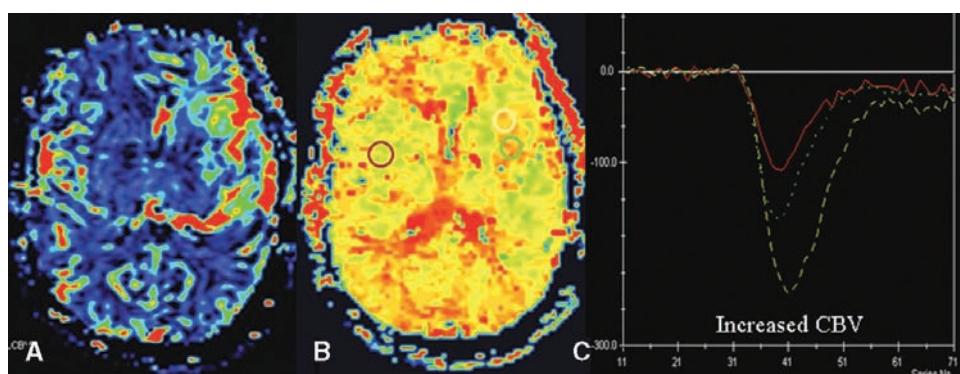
(A) Gradient-echo axial DSC MRI with rCBV color overlay map, and (B) MTT color overlay map demonstrates a high CBV in the lesion and the perilesional regions. (C) Signal intensity versus time curves color coded to the three ROIs placed on the MTT map demonstrates high CBV (area under the signal intensity curves) in the yellow ROI and to a lesser extent in the green ROI, which have been placed at the lesion, compared with the red ROI of the contralateral normal parenchyma. Increased CBV in the lesion and the perilesional regions was highly suggestive of a high-grade glioma with tumor infiltration into the surrounding tissues. In tumoral disease MTT/TTP may be increased or decreased and is less specific. The final diagnosis was anaplastic astrocytoma. Abbreviations: DSC MRI, dynamic susceptibility contrast MRI; rCBV, relative cerebral blood volume; MTT, mean transit time; ROI, region of interest; CBV, cerebral blood volume; TTP, time to peak.
